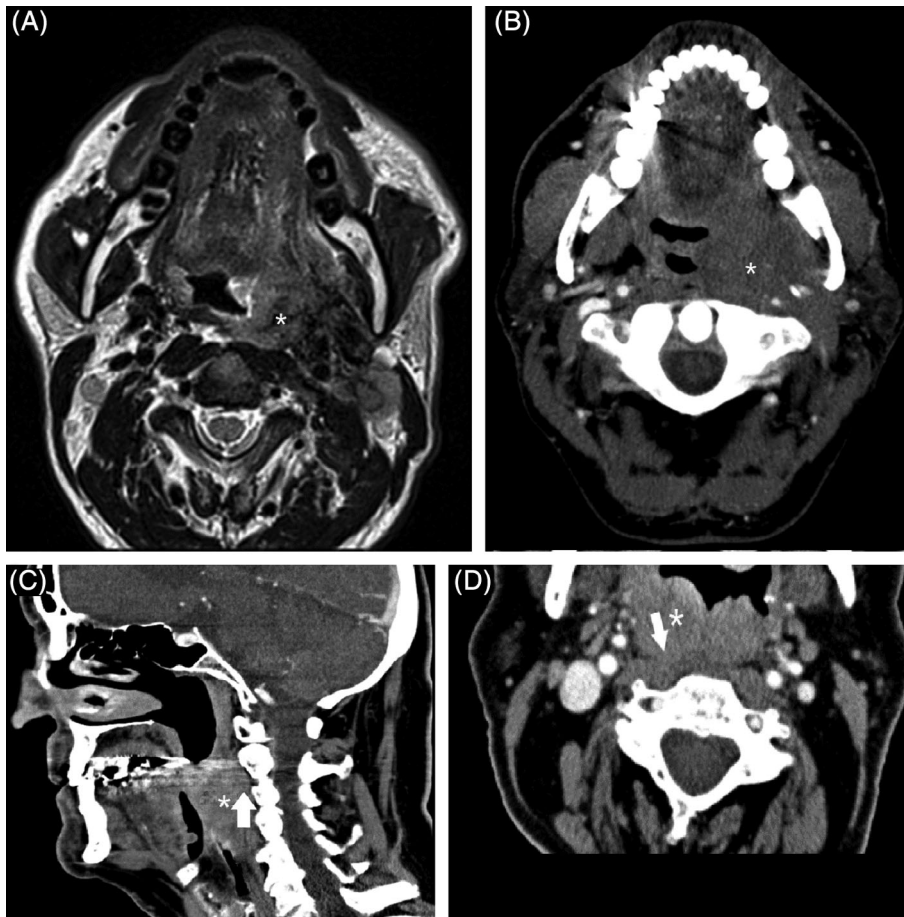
MR and CT images demonstrate absolute contraindications for transoral robotic surgery in tonsillar carcinoma. A and B, Axial T2-weighted MR and axial contrast-enhanced CT images show a left oropharyngeal tumor (*) that extends posterolaterally to encase the left carotid artery and also infiltrates the left masticator space. C and D, Sagittal and axial contrast-enhanced CT images show a lobulated oropharyngeal tumor extending posteriorly to involve the prevertebral space (*), as evidenced by focal loss of the prevertebral fat plane (white arrow)
